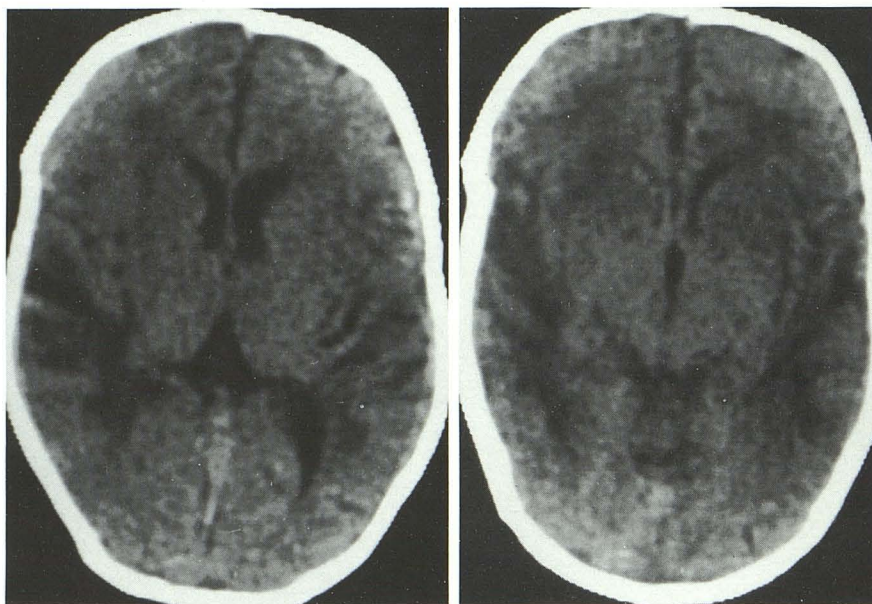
Menkes disease; 6-month-old boy with mental retardation and spasticity. A and B, Cranial CT; there is severe diffuse atrophy of the cerebral hemispheres, deep gray nuclei, and brain stem.
